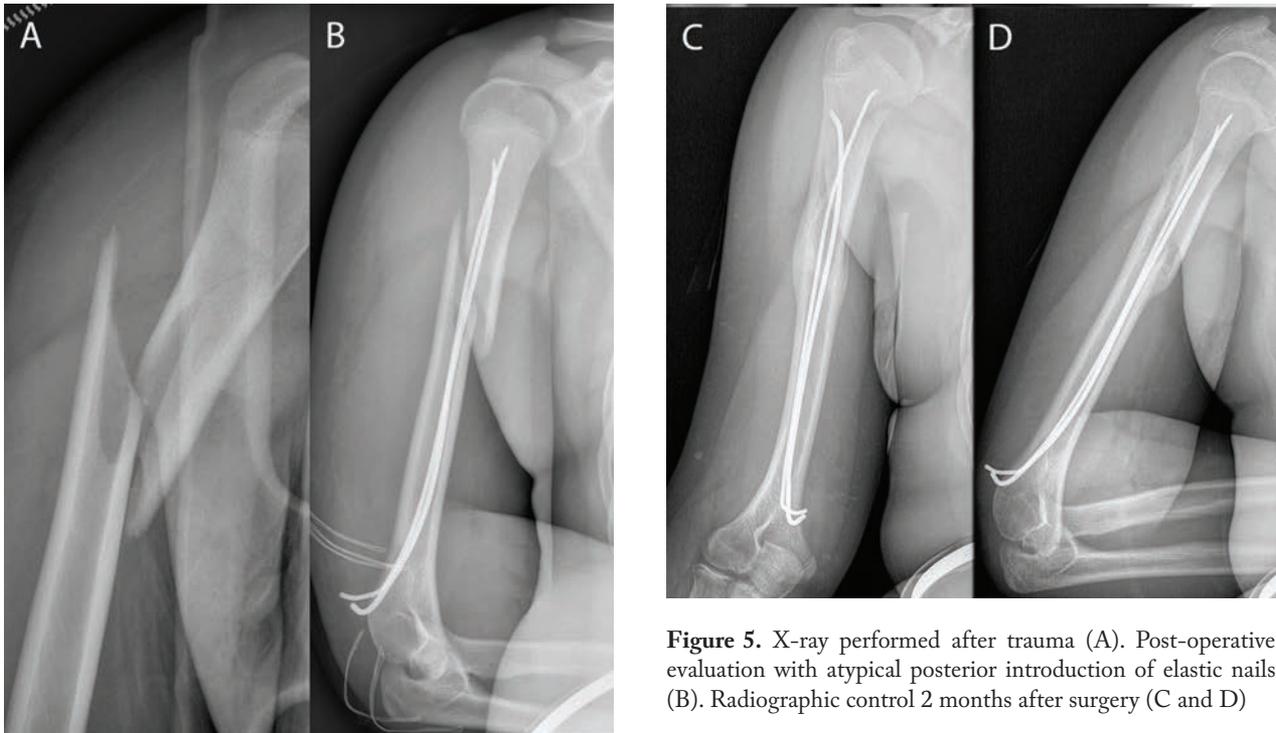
X-ray performed after trauma (A). Post-operative evaluation with atypical posterior introduction of elastic nails (B). Radiographic control 2 months after surgery (C and D)
